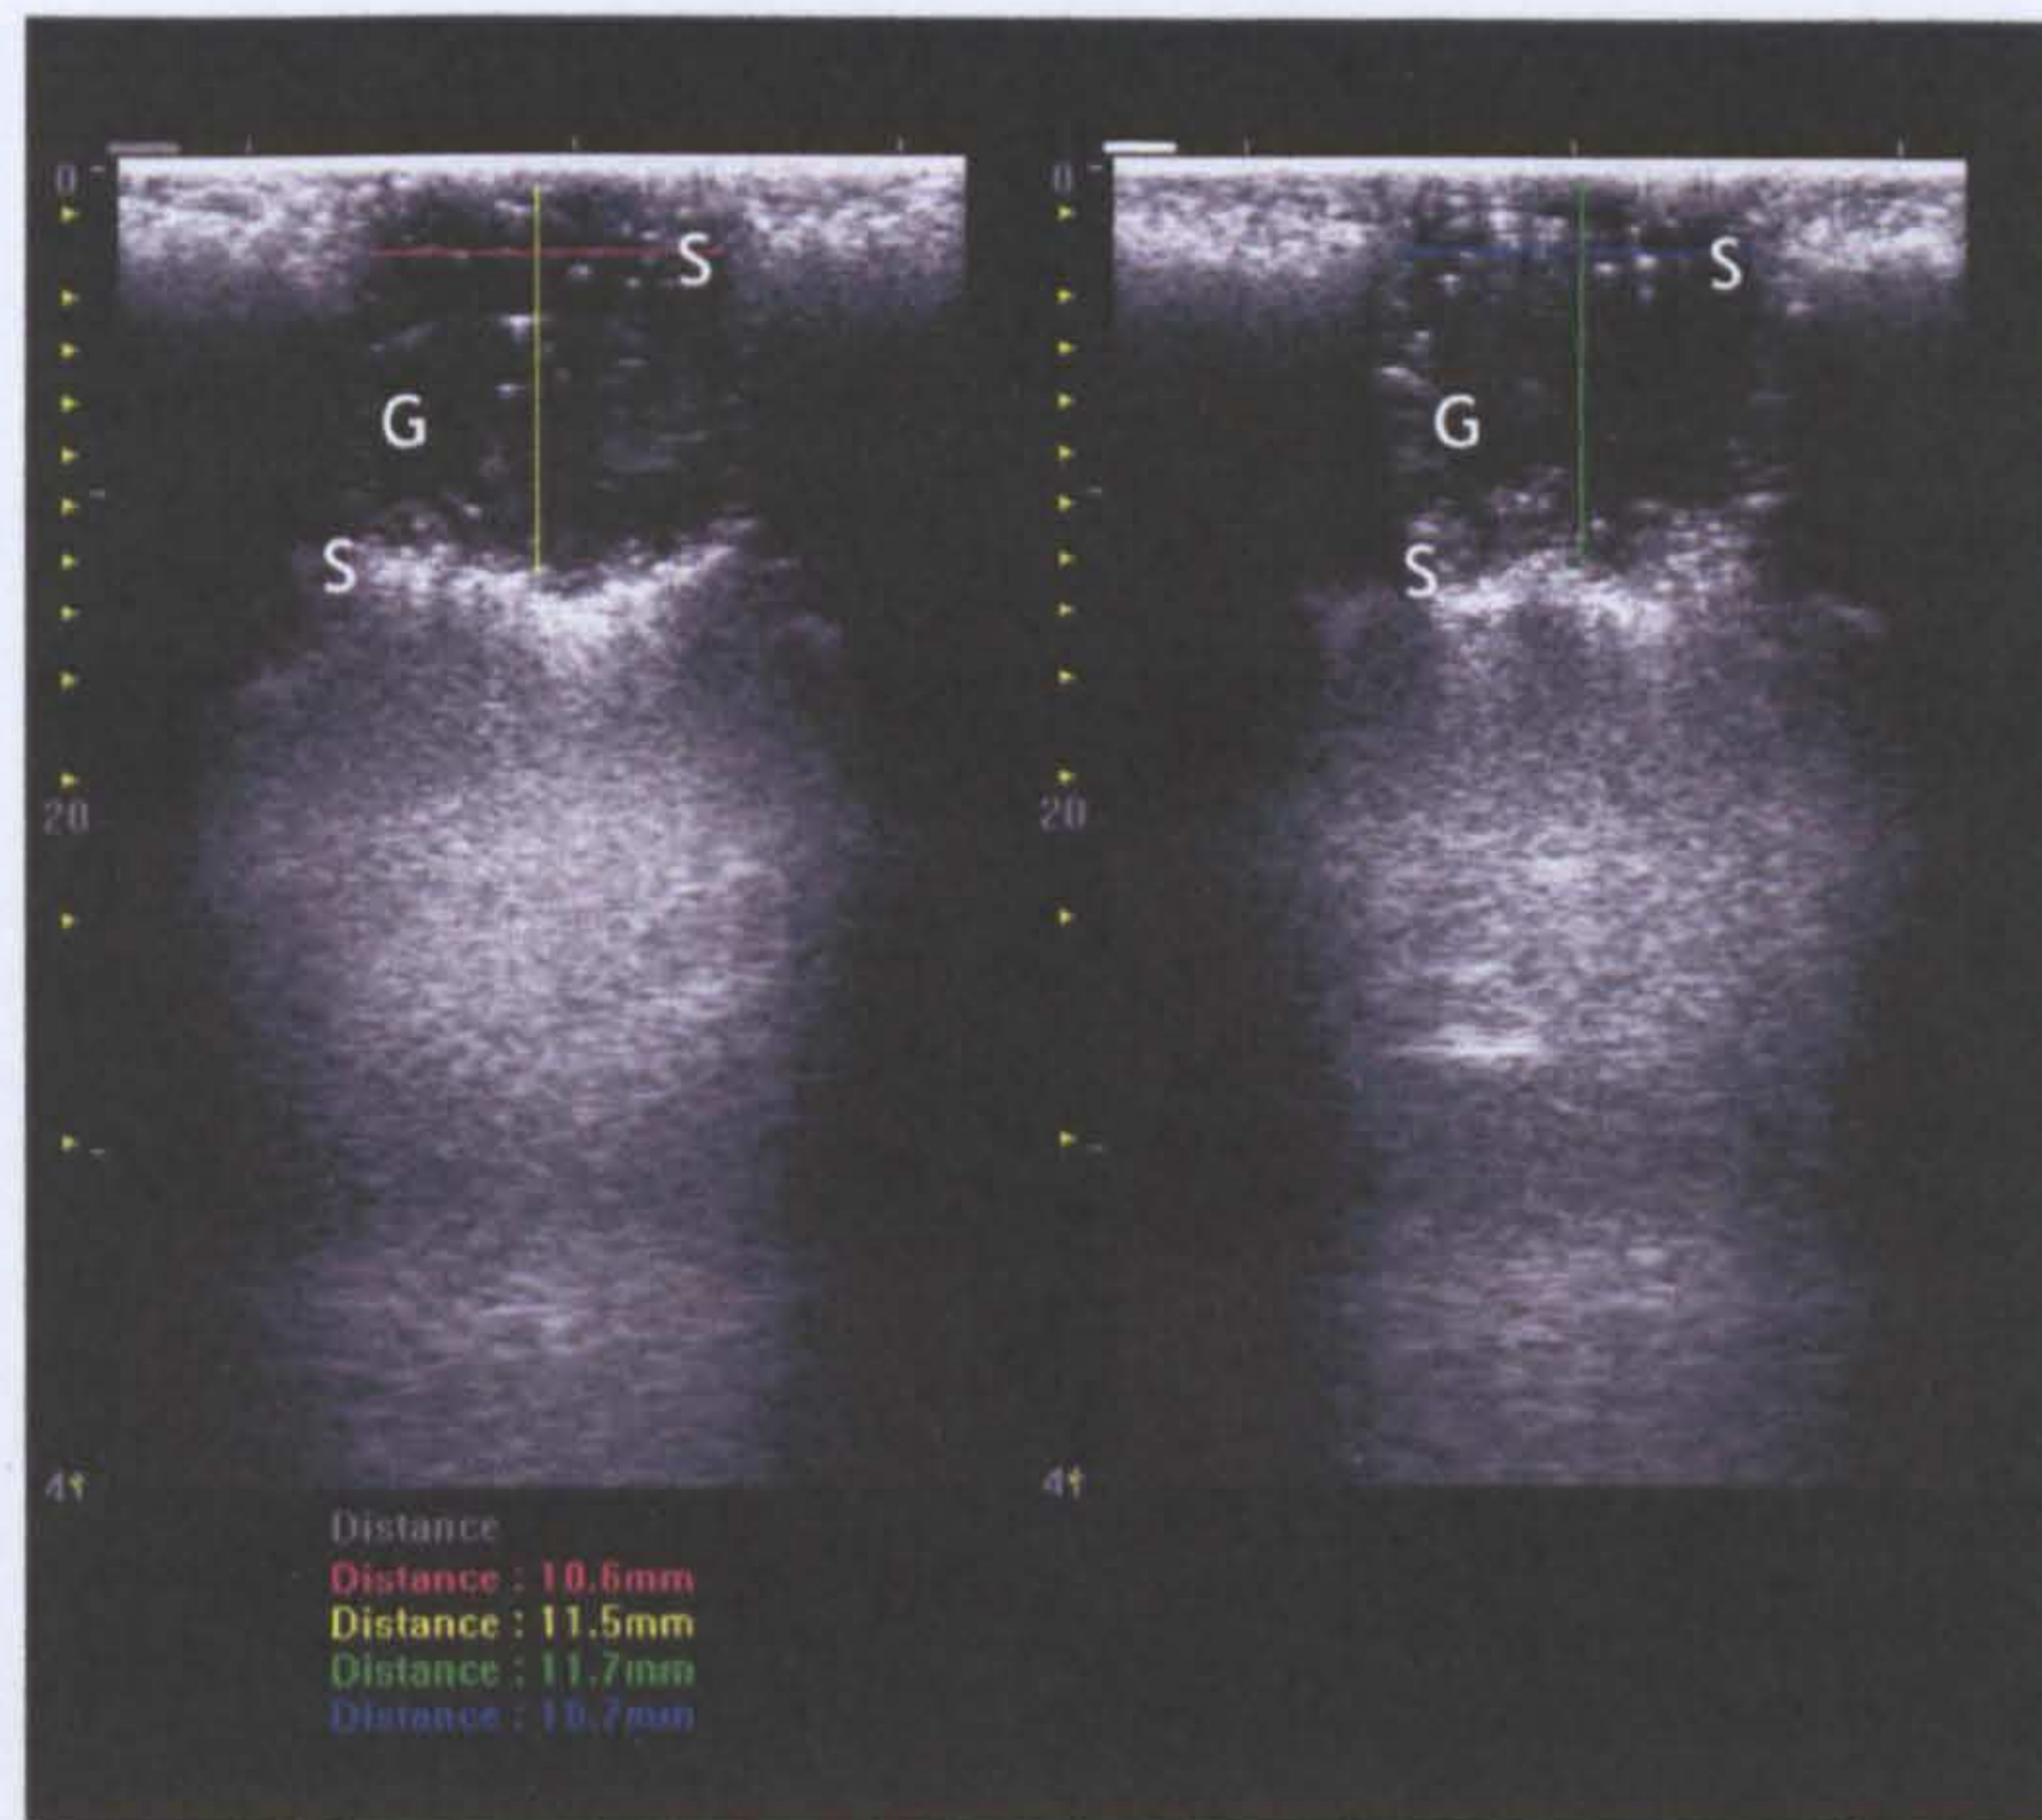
Ultrasound of synthetic lesion in sponge
